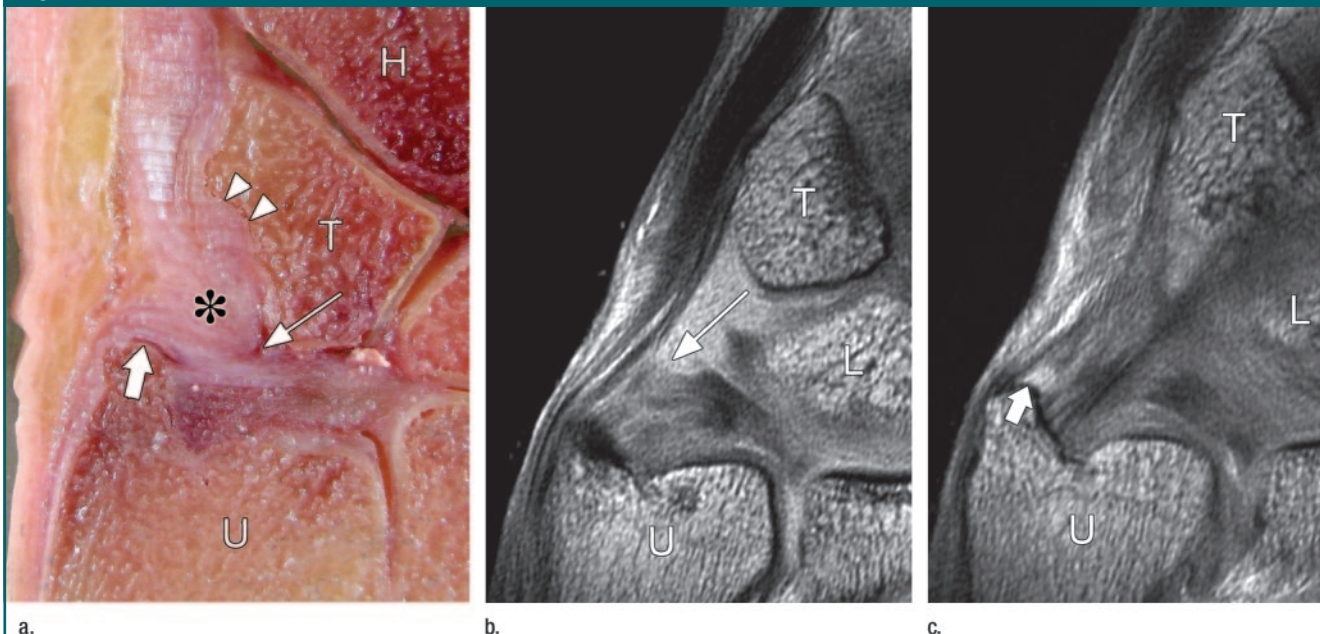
No-opening UMH type with respect to the entrance to the prestyloid recess. (a) Anatomic section and (b, c) intermediate-weighted MR images obtained with the wrist in maximal radial deviation are shown. T = triquetrum, U = ulna. In a, there is no communication between the small prestyloid recess (thick arrow) and the radiocarpal joint space (thin arrow), and the UMH (*) is relatively large and has a broad attachment (arrowheads) to the ulnar aspect of the triquetrum. H = hamate bone. In b and c, there is also no communication between the radiocarpal joint space (thin arrow in b) and the small prestyloid recess (thick arrow in c) at the tip of the ulnar styloid process. L = lunate bone.
